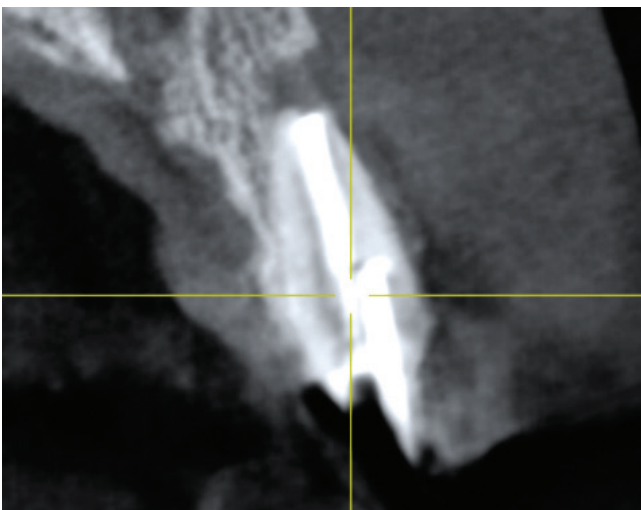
A CBCT scan rules out the placement of an immediate implant due to a very deficient buccal plate, and significant bone loss in the sinus tract area.*
